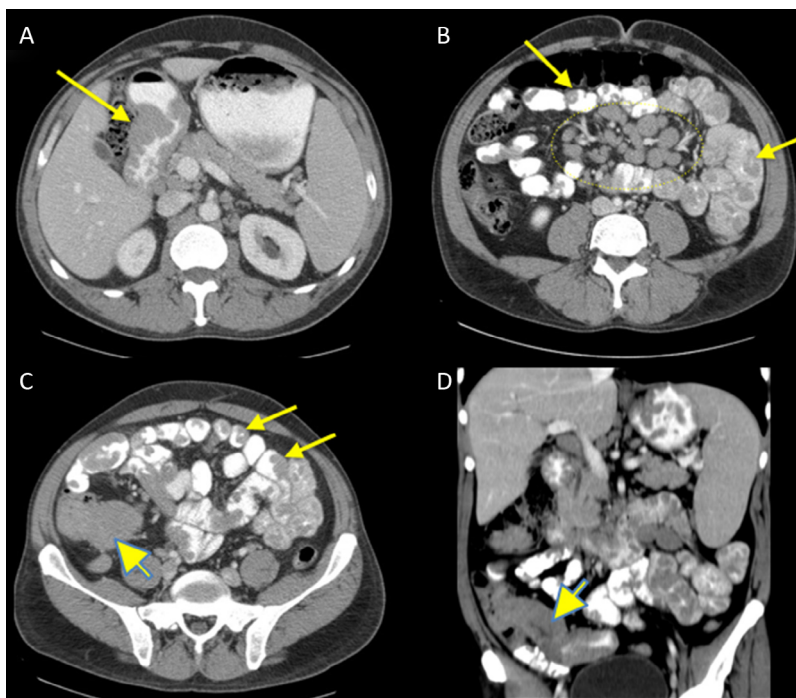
Axial (A, B, and C) and coronal (D) post-contrast computed tomography (CT) showing multiple polyps throughout the small bowel and colons (arrows) and also lymphadenopathy (dotted circle). Notice diffuse terminal ileum thickening (C and D), palpable on physical examination (arrowhead).
